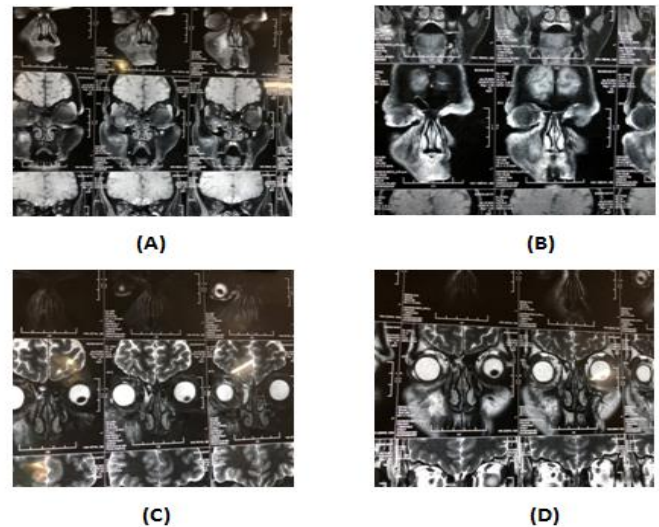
Contrast CT Scans and MRI showing right maxillary sinusitis and involvement of right extraocular muscles
